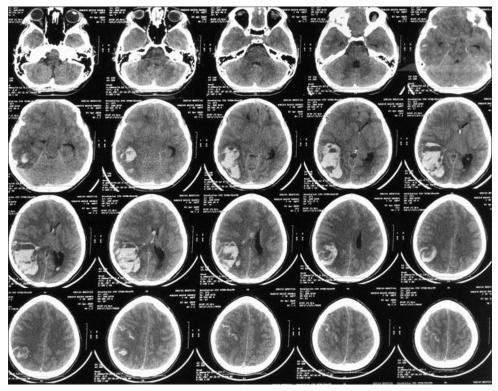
Case 2 noncontrast computed tomography scan showed right occipito-temporal hematoma with midline shift and slight extension to ventricle. Note hypodensity of the ipsilateral hemisphere.
